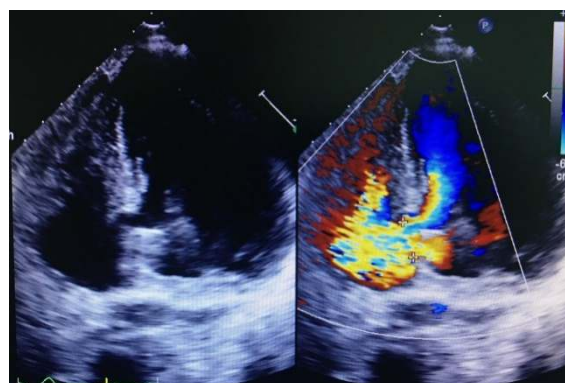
Pre-operative transthoracic echocardiogram shows a ventricular septal rupture with left-to right shunt flow.
